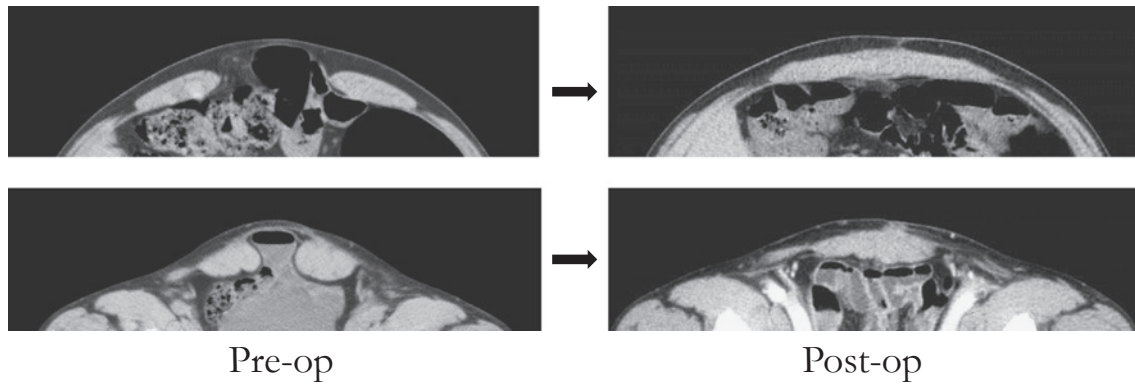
CT scans in patient after anterior component separation repair
